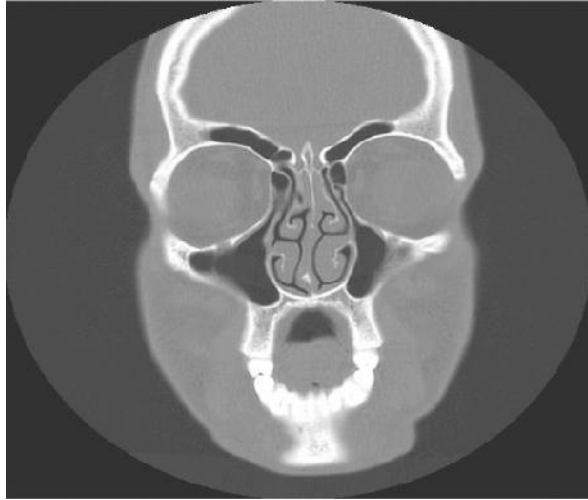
Coronal CT image showing paradoxical turn of middle turbinates.
